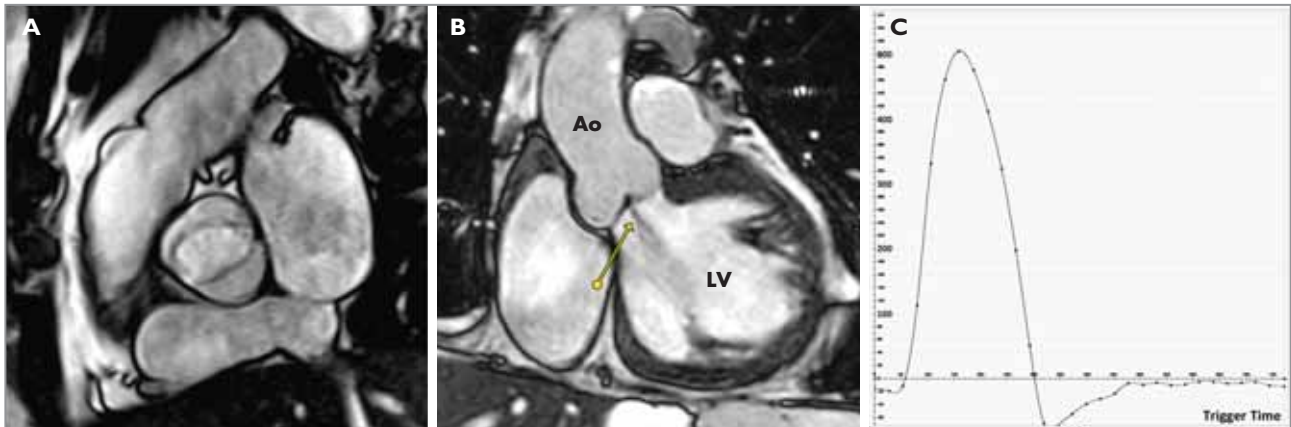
Bicuspid aortic valve regurgitation. Magnetic resonance imaging (MRI) shows (A) a short axis view of the bicuspid valve in systole (B) a long axis view in diastole showing the regurgitant jet (arrow). As with colour Doppler, the jet itself is not accurate for determining severity of regurgitation. (C) A MRI derived flow curve in the ascending aorta demonstrates forward flow in systole and reverse flow in diastole due to AR. This approach allows accurate quantitation of regurgitant volume and fraction.
